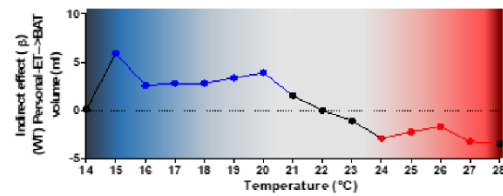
A) Mediation models of the relationship between the number of hours exposed to a certain Personal-ET and BAT-related outcomes in young adults. Path c shows the association between independent and dependent variables. Arrows a x b show the natural indirect effect (β) pathway, and c' shows the natural direct effect pathway. B) Indirect effects (β) of the simple mediation analyses of wrist temperature on the association between the number of hours exposed to each degree of Personal-ET (from 14°C to 28°C) and BAT volume, whereas panels C and D refer to BAT SUV_{peak} and metabolic activity, respectively. E) P_M of the simple mediation analyses of wrist temperature on the association between the number of hours exposed to each degree of personal-ET (from 14°C to 28°C) and BAT volume, whereas panels F and G refer to BAT SUV_{peak} and metabolic activity, respectively. Black dots represent that 0 was in the 95% confidence interval of the indirect effect, and, therefore, the mediation was considered non-statistically significant (P>0.05). Red and blue dots mean that the mediation analysis was statistically significant but with a different direction. BAT: brown adipose tissue; Personal-ET: personal level of environmental temperature; WT: wrist skin temperature; P_M: Percentage of mediation.
